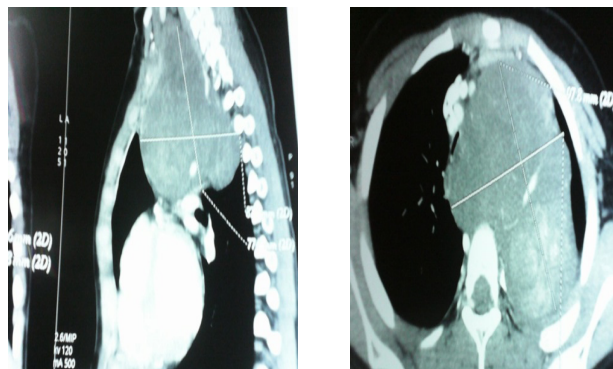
Chest CT image of the lower cervical region showing the presence of a mediastinal mass with low cervical extension
